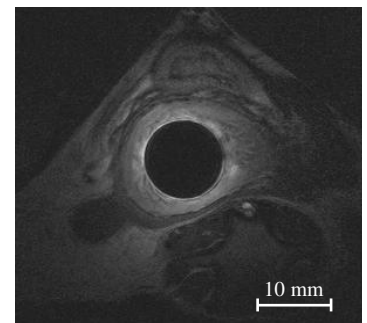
Axial T2-weighted TSE images (TR/TE : 3000/82 ms; FOV = 80 mm; 2.5 mm slice thickness; 156 x 195  $\mu\text{m}^2$  pixel size; 5 min 40 s scan time) showing the internal and external sphincters.
